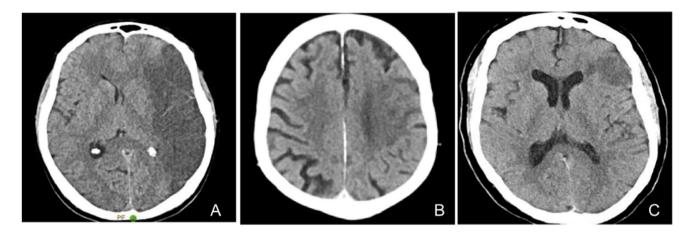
CT Head imaging on admission showing evolving acute left MCA infarction in patient 1 (A), patient 2 (B), and patient 3 (C)
